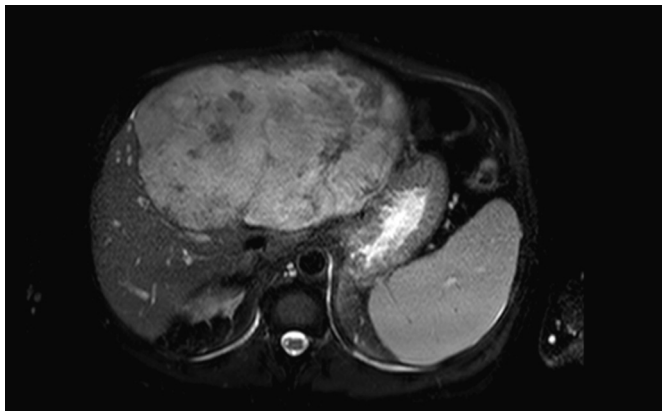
MRI showing a large mass in the left liver.
